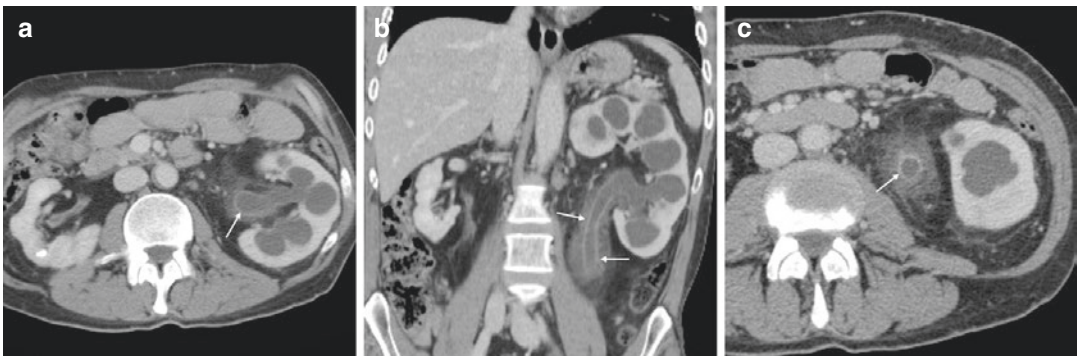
A 44-year-old male had history long-standing HIV infection on antiretroviral treatment, known left-sided hydronephrosis and previously resected nephrogenic adenoma of the urinary bladder. Currently suffering from fever and macroscopic haematuria, he underwent contrast-enhanced CT (a–c) which showed worsening
